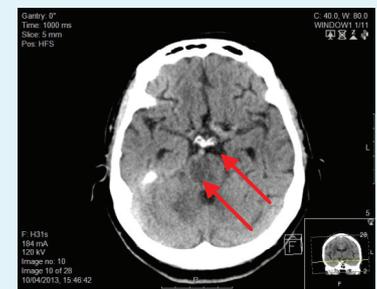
Non-enhanced CT of the brain. Hypodense appearance of brainstem and parts of the right cerebellar hemisphere in keeping with now demarcated subacute ischaemic changes.
